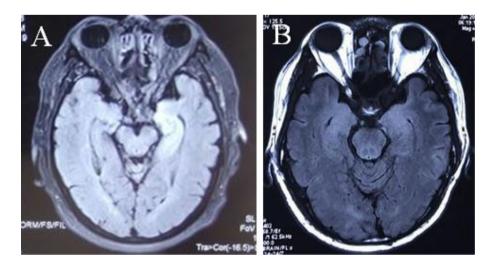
(A) Seventy years old male with LGI1 antibody: MRI showing left amygdala and hippocampus FLAIR hyperintensity. (B) Forty-nine years old male with LGI1 antibody: MRI showing bilateral amygdala and hippocampus FLAIR hyperintensities.
